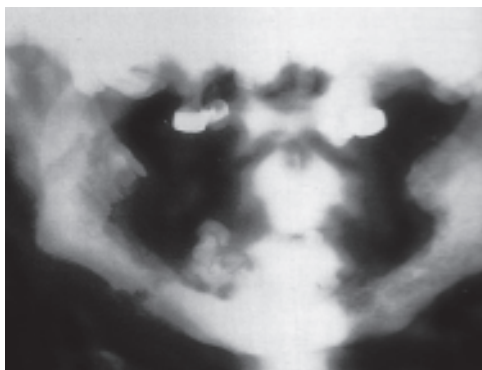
Panoramic radiograph of osteopetrosis showing a pathologic fracture, a retained tooth and a bone sequestrum, all of which are typical of the disease
